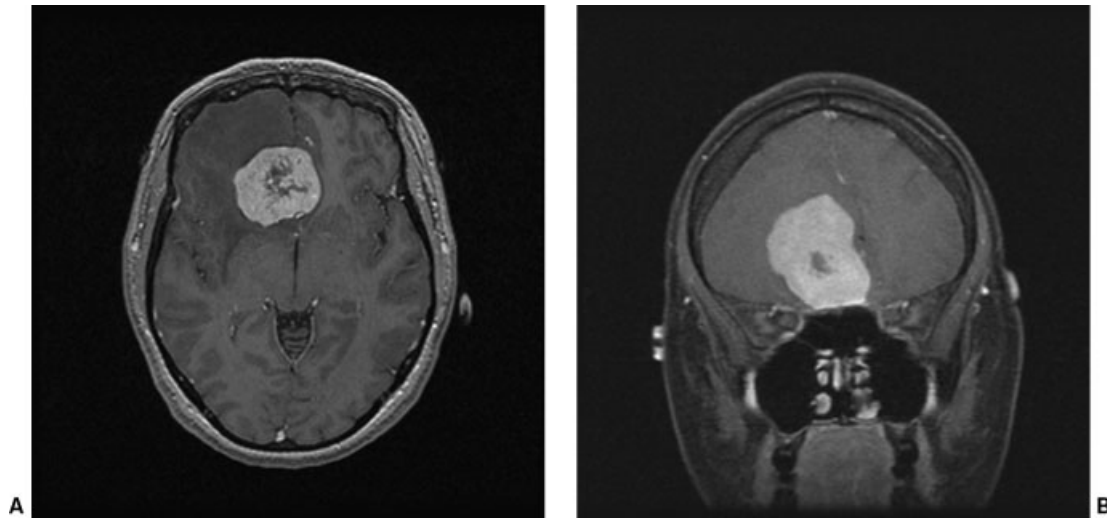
Preoperative (A) axial and (B) coronal T1-weighted MRIs show a 4-cm homogeneous extra-axial mass with central necrosis, consistent with a meningioma.
